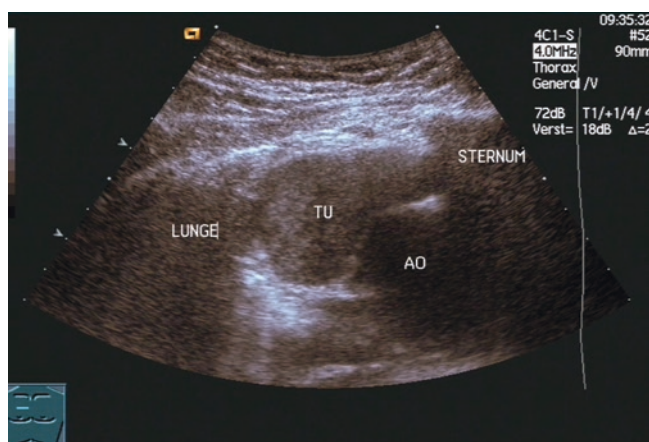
A 56-year-old woman with retrosternal pain caused by a thymoma (TU) broad adjacent to the aortic wall. Diagnosis was established with sonographic biopsy and confirmed by operation
